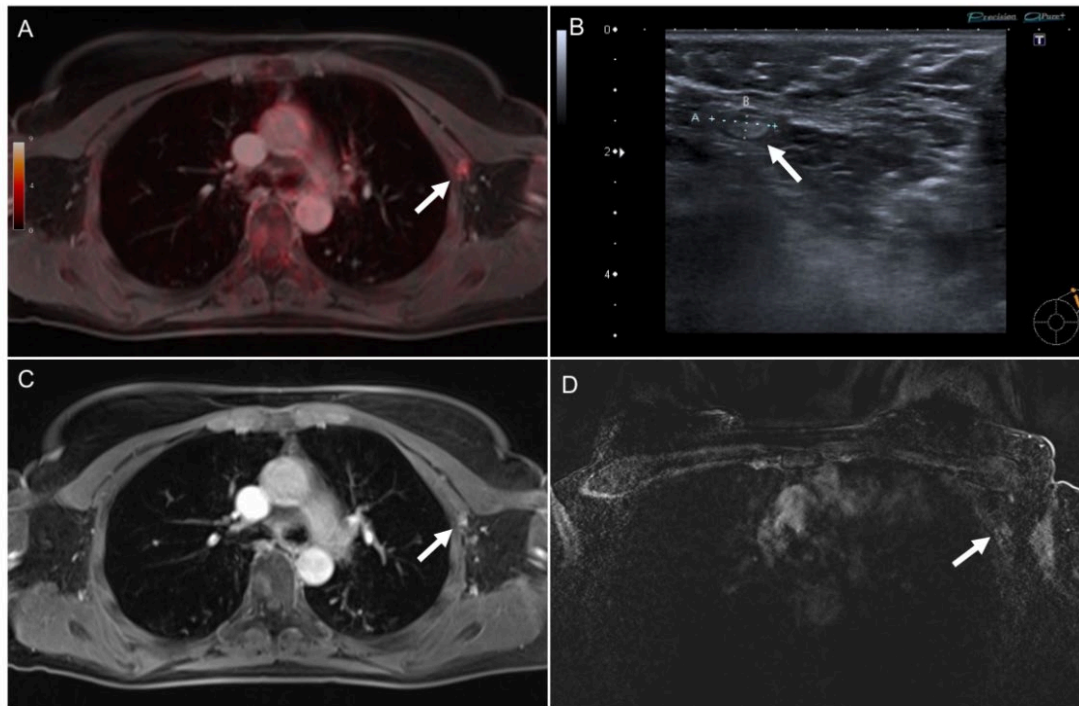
Pathologically confirmed axillary lymph node metastasis that was correctly identified in FDG PET/MRI (A) because of its tracer uptake above the background (SUVmax 4.7). This lymph node was rated false negative in axillary sonography (B), thoracic MRI (C), and breast MRI (D). *Reprinted with permission from Morawitz J et al. JNM May 2021; DOI: <https://doi.org/10.2967/jnumed.121.262009>.*
